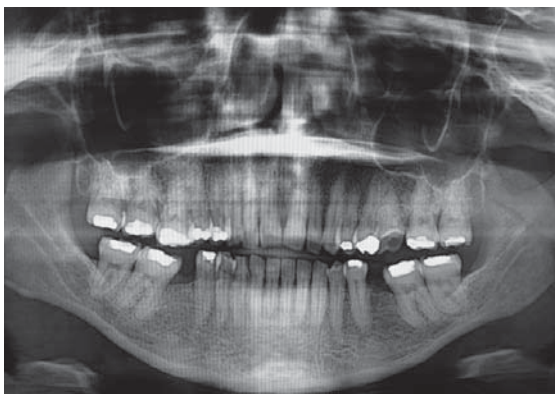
Orthopantomography showing horizontal bone loss in both arches.
